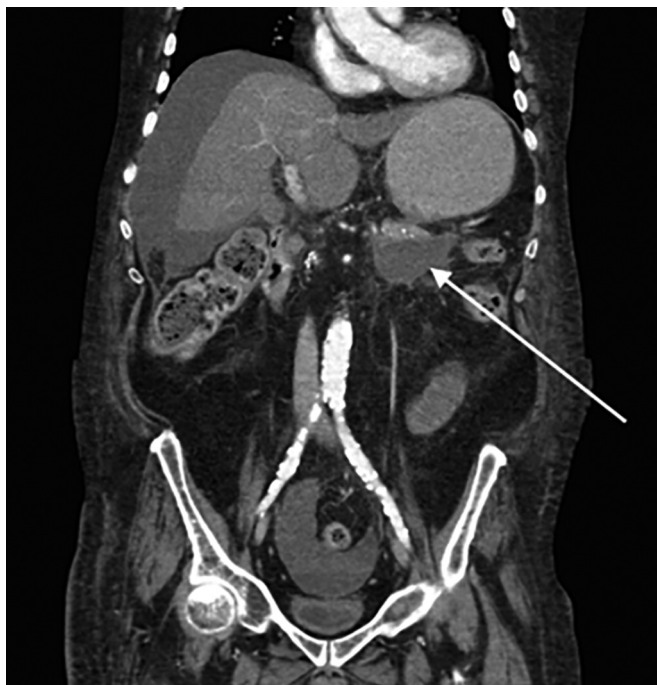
Coronal view from a computed tomogram (CT) of the abdomen, showing an 8.2-cm by 5-cm peripancreatic abscess (arrow).
